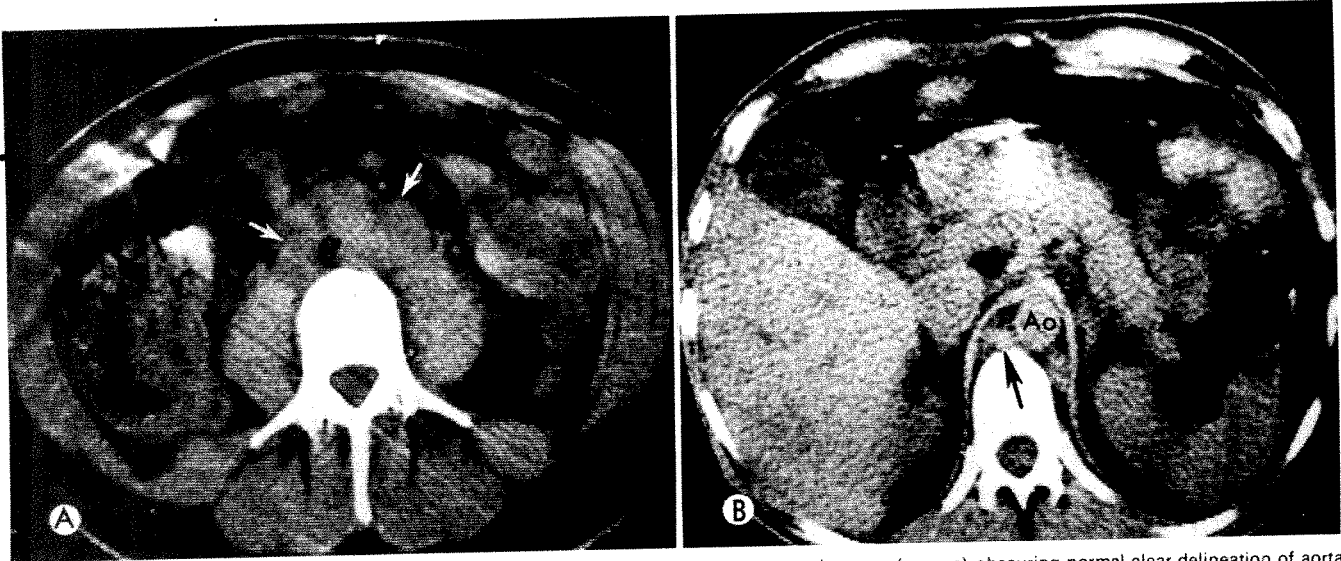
CT scans of 40-year-old man with fever of unknown origin. *A*, Masses in retroperitoneum (arrows) obscuring normal clear delineation of aorta and vena cava. *B*, Scan at higher level showing moderately enlarged lymph nodes posterior to diaphragmatic crura (arrow) on either side of aorta (Ao). With increasing enlargement of these nodes, widened paravertebral stripe becomes apparent on conventional plain films of chest or upper abdomen. Laparotomy disclosed enlarged paraaortic and paracaval retroperitoneal lymph nodes secondary to histiocytic lymphoma.
